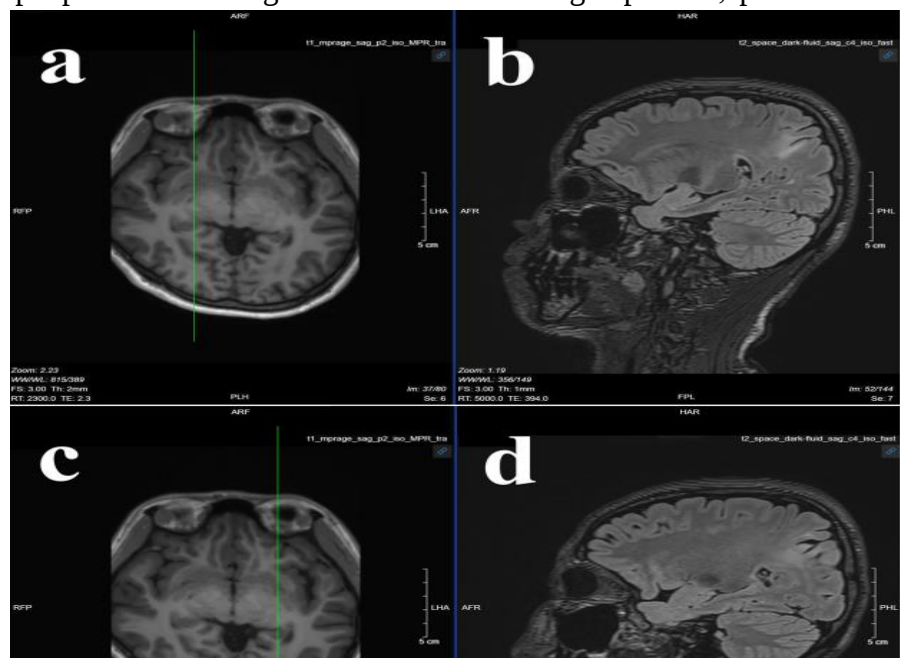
The right parietal and left occipital lobes of high-resolution hippocampus MRI images have patchy Flair hyperintensity, indicating the necessity for a contrast-enhanced cranial plain CT scan. Plain MRI scans of both hippocampi did not reveal any obvious abnormalities. A) image transversely. b) Patchy Flair hyperintensity in the right parietal lobe on a sagittal scan. C) Image transverse. D) Patchy Flair hyperintensity in the left occipital lobe in the sagittal picture
